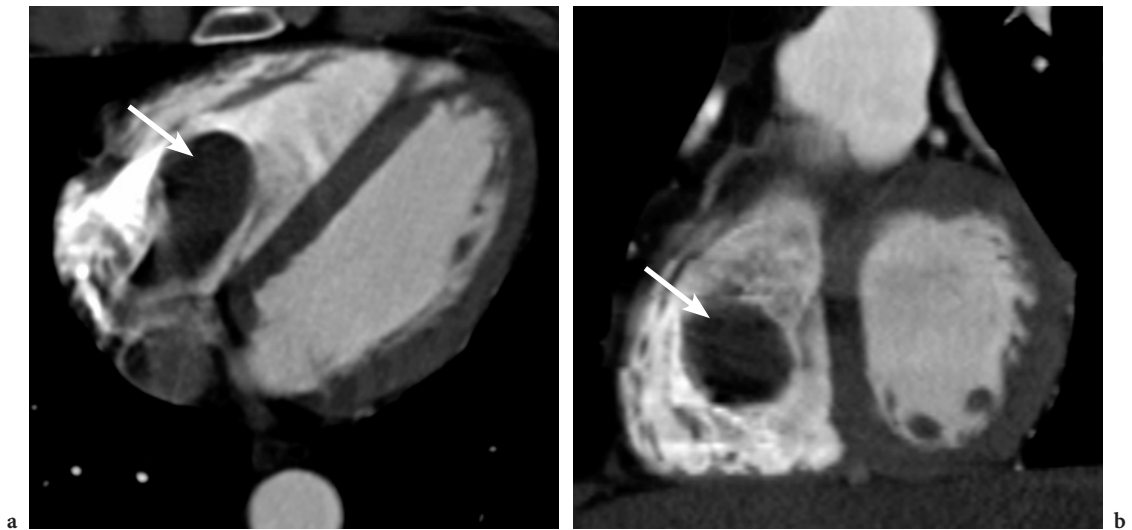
64-slice CT examination of a patient with a heart rate of 89–97 bpm during the scan. A shorter contrast delay time was selected such that both left and right ventricles show enhancement. Axial slice (a) and MPR (b) reveal a thrombus in the right ventricle (*arrow*). The fast rotation speed of 0.33 s enables high temporal resolution and image reconstruction free of motion artifacts
